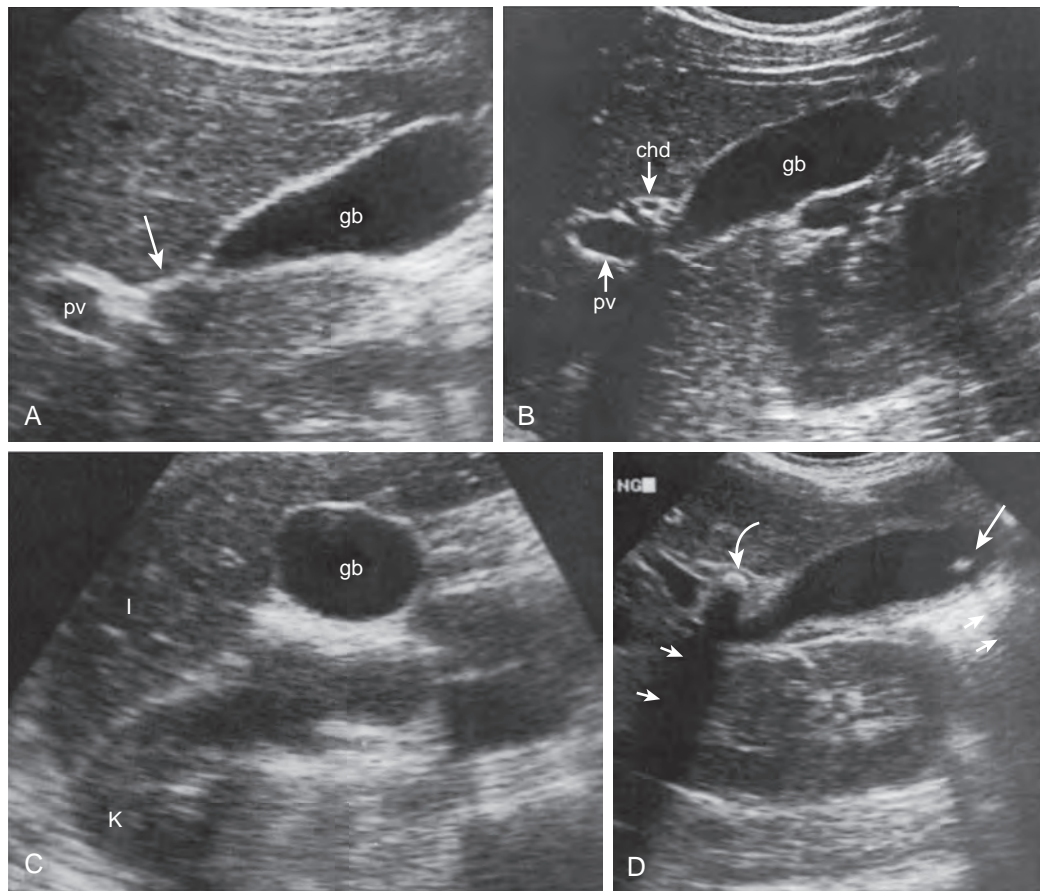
Normal gallbladder anatomy: sonography. A. The linear echogenic line (arrow) of the interlobar fissure bears a constant relationship to the gallbladder neck and aids in sonographic localization of the gallbladder (gb). pv, Portal vein. B. Longitudinal sonogram of the normal gallbladder (gb). Note the relationship of the gallbladder neck to the portal vein (pv, arrow) and common hepatic duct (chd, arrow). C. Transverse sonogram of the normal gallbladder (gb). Note the relationship to the liver (l) and the kidney (K). D. Sonogram shows a stone in a dependent position in the gallbladder (long arrow). A second stone behind the fold and impacted in the neck of the gallbladder (curved arrow) was seen only after careful evaluation of the neck in the erect position. Both stones cast characteristic acoustic shadows (short arrows).
